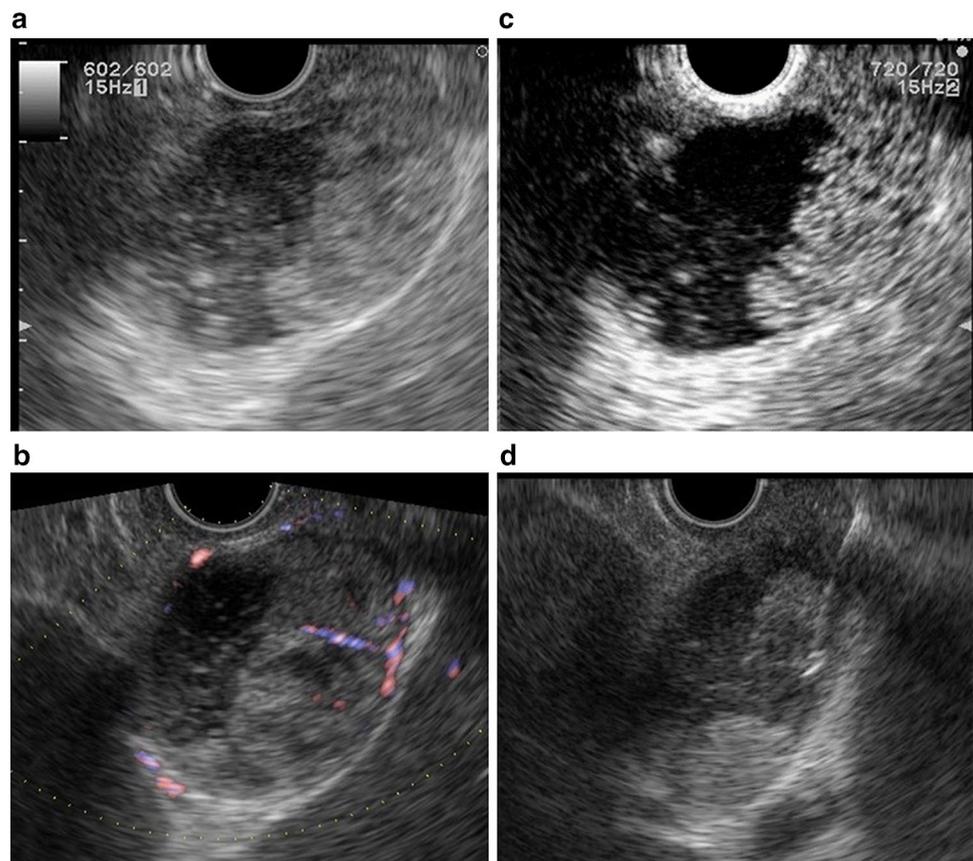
Endoscopic ultrasonography (EUS) findings. a Well-defined isoechoic heterogeneous mass arising from the gallbladder wall. b Power Doppler EUS reveals increased flow inside the tumor. c Sonazoid-enhanced EUS also showed hypervascularity of the gallbladder tumor. d Transduodenal EUS-FNA of the gallbladder mass, using a 25-gauge FNA needle
